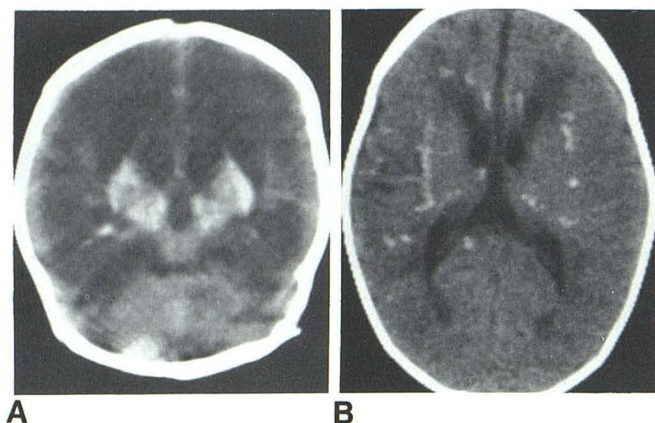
Unenhanced CT scans in two infants late in course of neonatal HSE showing different patterns of increased attenuation. A, Case 4. Increased attenuation in thalamus and lateral basal ganglia with widespread parenchymal destruction. Combination of hemorrhage and calcification with multicystic encephalomalacia probably accounts for findings, judging from similarity to case 2 (fig. 2). B, Case 3. Multifocal areas of increased attenuation, presumably calcifications because of punctate nature and lack of adjacent edema. Similar densities in temporal and frontal lobes (cf. fig. 3B) and centrum semiovale on scans at different levels. Also mild dilatation of lateral and third ventricles.
